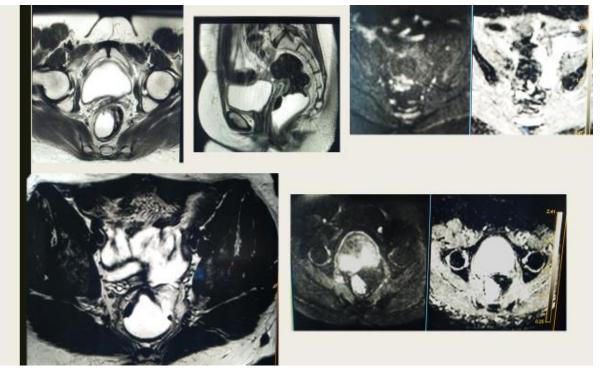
42 year old female ptient who had mid-upper level disease at 11-2 o'clock position who then underwent long course treatment. The patient exhibited near-complete response in her post-treatment MR images
